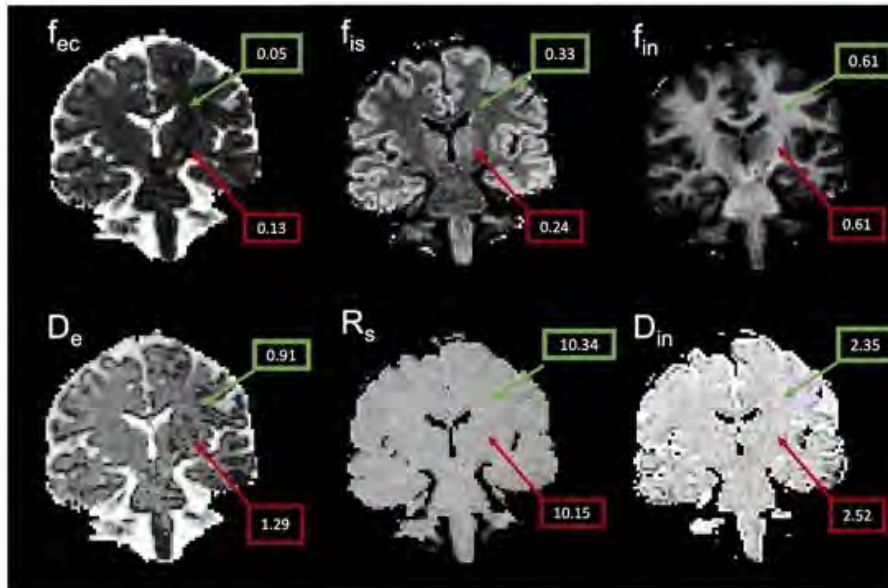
SANDI parameter maps derived from DWI data in a representative migraine patient.
